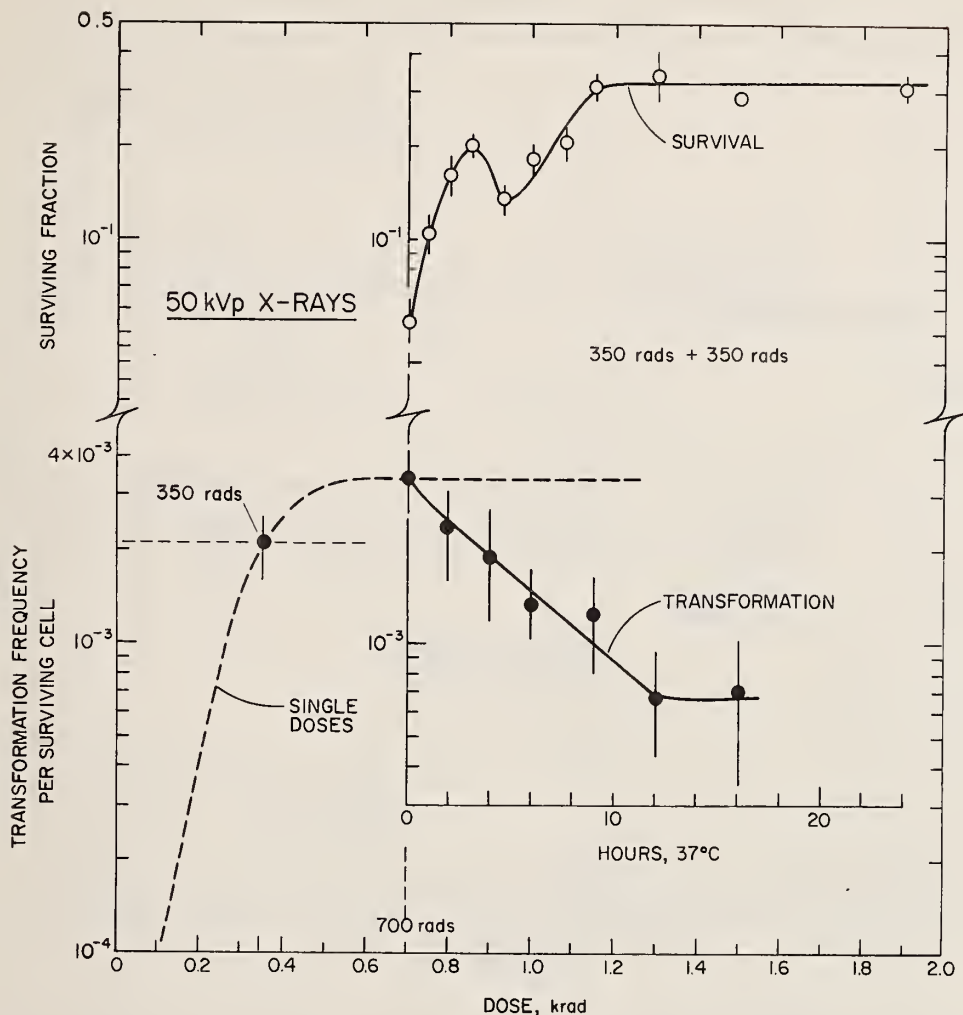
Changes in survival and transformation frequency per survivor in C3H/10T1/2 cells exposed to fractionated doses of 50 kVp X-rays. Cell survival (O); transformation (●). Error bars represent standard errors of the pooled data from different experiments. The single-dose induction curve (dashed line) comes from Fig. 3. Inset abscissa, time at 37°C between the two exposures; the 0 fractionation time is plotted from the total dose of 700 rads. (From Han and Elkind, *Cancer Res.* 39, 123-130, 1979)
